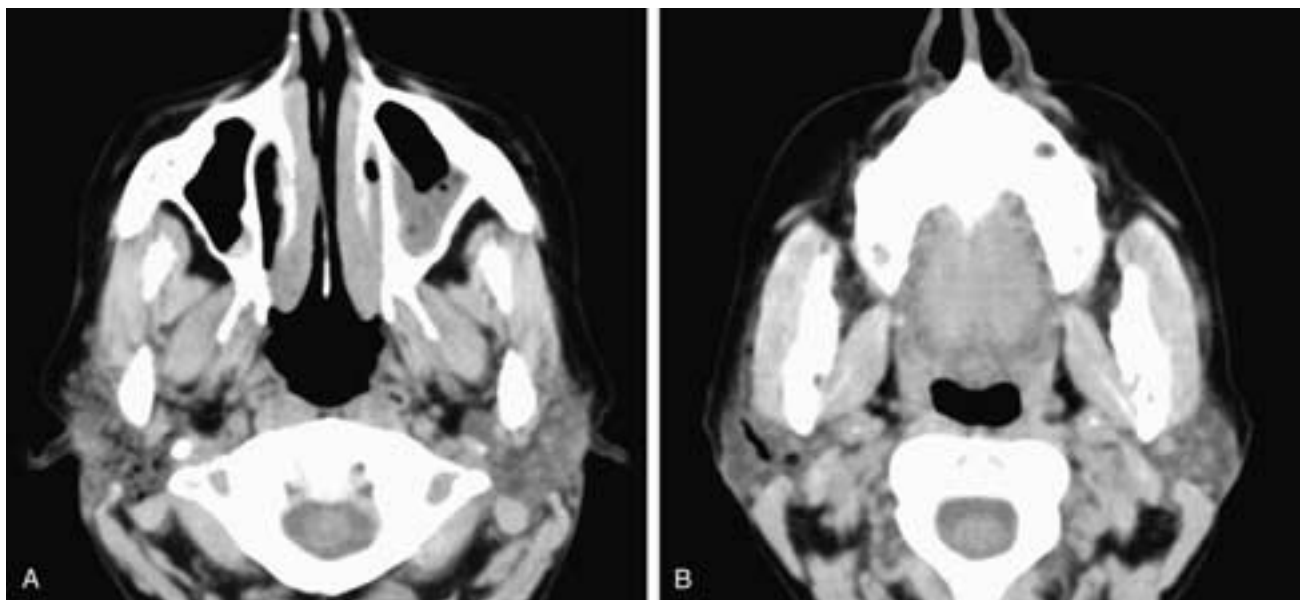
Axial CT scans through the upper (A) and lower (B) parotid glands. There is air within the right parotid ducts, and a small amount of air is seen in Stensen's duct. This patient had pneumoparotitis.
